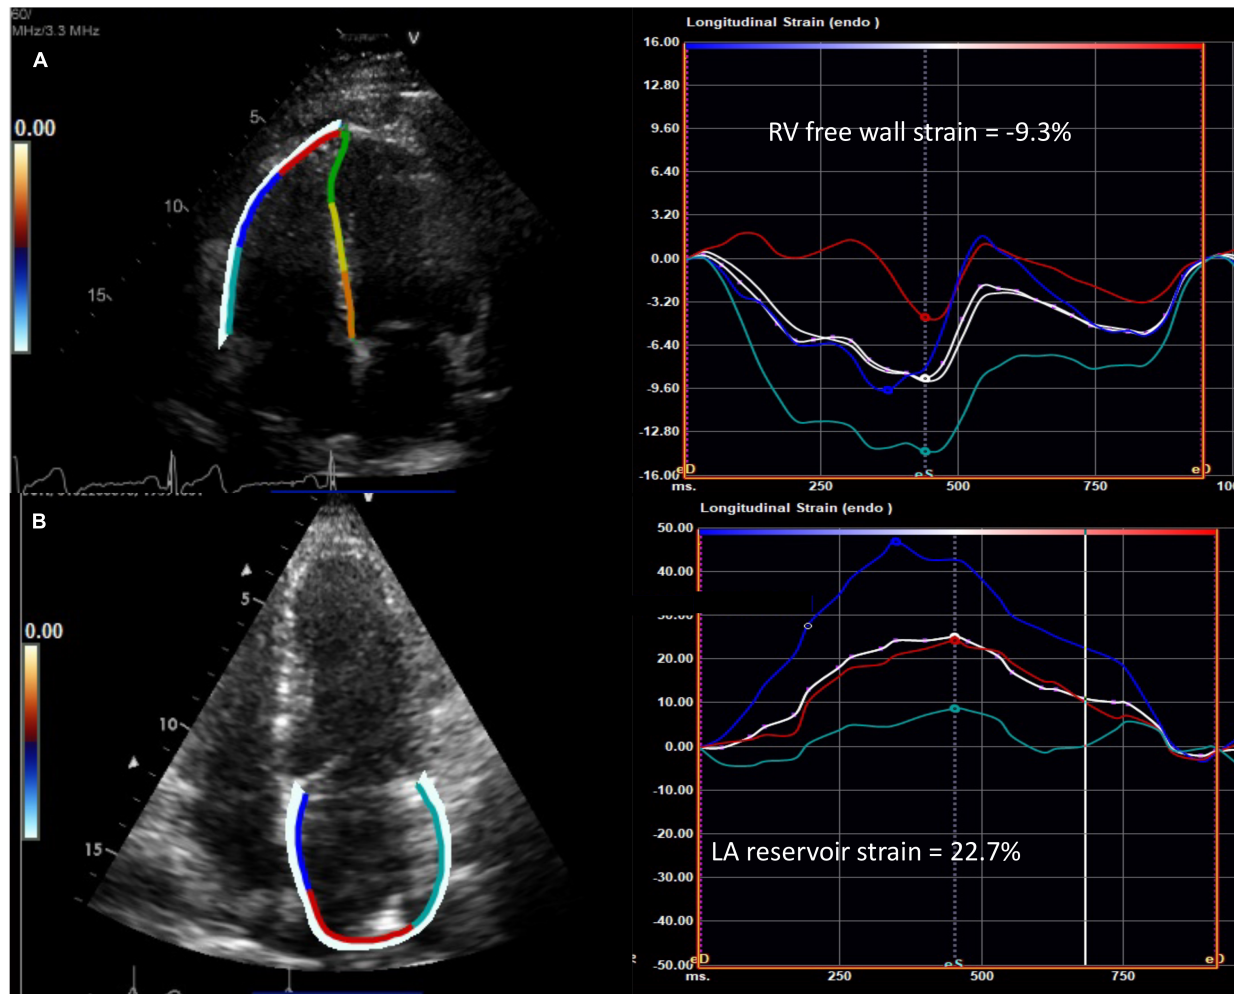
Abnormal speckle tracking strain in diffuse cutaneous systemic sclerosis. (A) Example of reduced right ventricular free wall strain (normal $<-20\%$) and (B) reduced left atrial reservoir strain (normal $>39\%$) from the apical four chamber view in patients with systemic sclerosis. The white curve represents the average of the peak systolic strain curves. RV, right ventricle; LA, left atrium.
